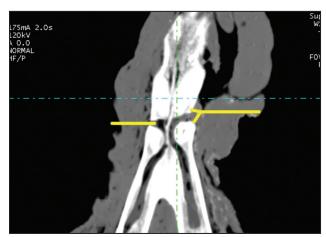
Dorsal plane of CT showing hollow passage of mandibular and mental canal communicating particularly at cranial to the alveolus of 1st premolar tooth.
